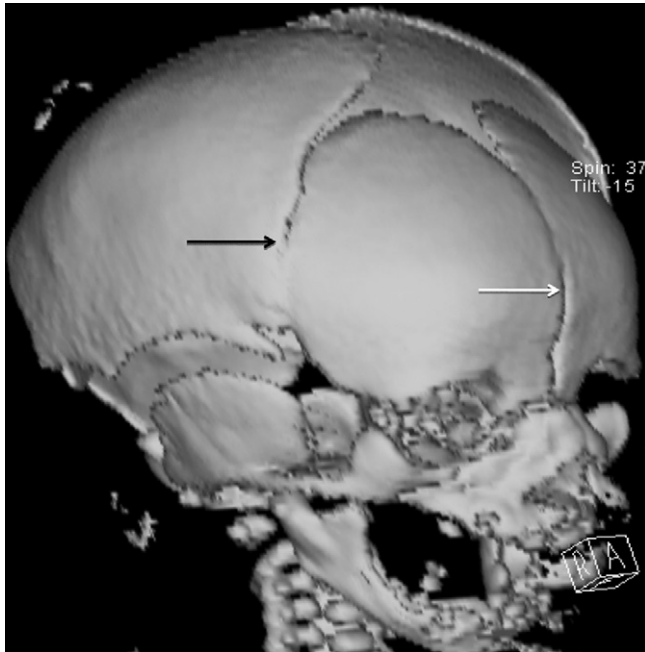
Three-dimensional computed tomography scans of the skull shows premature synostosis of the metopic and coronal sutures.
